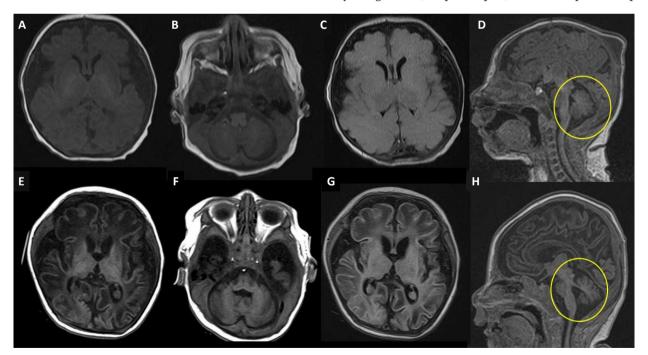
Brain magnetic resonance imaging (MRI) scans. Upper row at day 1 of life (A-D), lower row at 2 months (E, F). (A, B, E, F) Axial T1-weighted images; (C, G) axial T2-weighted axial fluid-attenuated inversion recovery (FLAIR) images; and (D, H) sagittal T1-weighted images. (A-D) Brain MRI on day 1 showed a diffusely decreased volume of the cerebrum with a markedly prominent subarachnoid space and operculum widening with normal myelination. However, there were no demonstrable abnormal signal changes in the basal ganglia or the thalami. (E-H) Brain MRI at 2 months showed suspicious cystic encephalomalacia changes in bilateral parietal areas and progressive atrophy of the cerebrum, cerebellum, and brainstem (circles on E, F).
